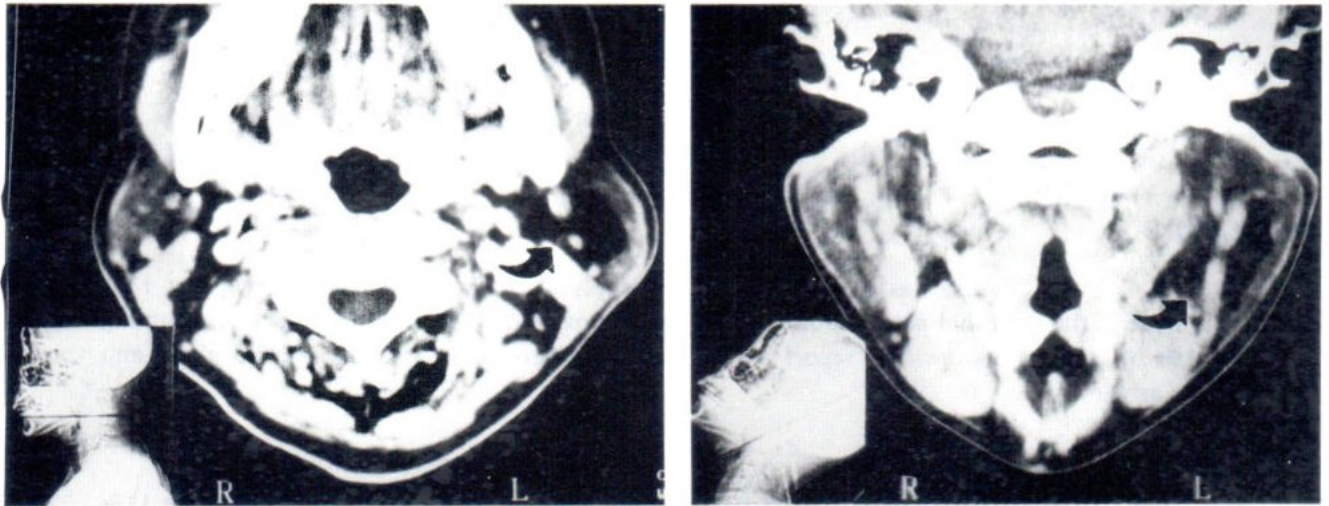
Post contrast (a) axial and (b) coronal CT scan showed left parotid lipoma with rim of normal parotid gland overlying lateral margin. Posterior facial vein and external carotid artery were well seen lying within the mass.
